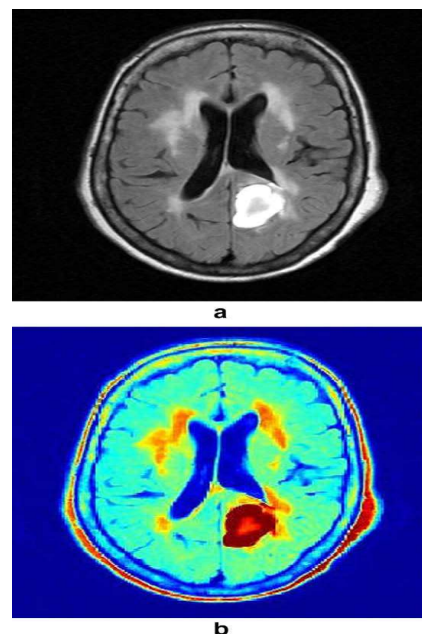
Original MRI T2-weighted brain Images, (a) gray-level image and (b) Color image
